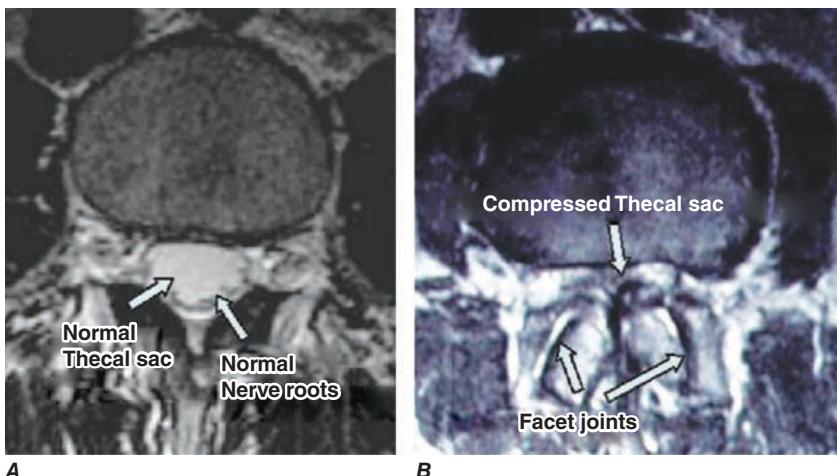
Spinal stenosis. A, An axial T2-weighted image of the normal lumbar spine shows a normal thecal sac within the lumbar spinal canal. The thecal sac is bright. The lumbar roots are seen as dark punctate dots located posteriorly in the thecal sac. B, The thecal sac is not well visualized due to severe lumbar spinal canal stenosis, partially the result of hypertrophic facet joints.
